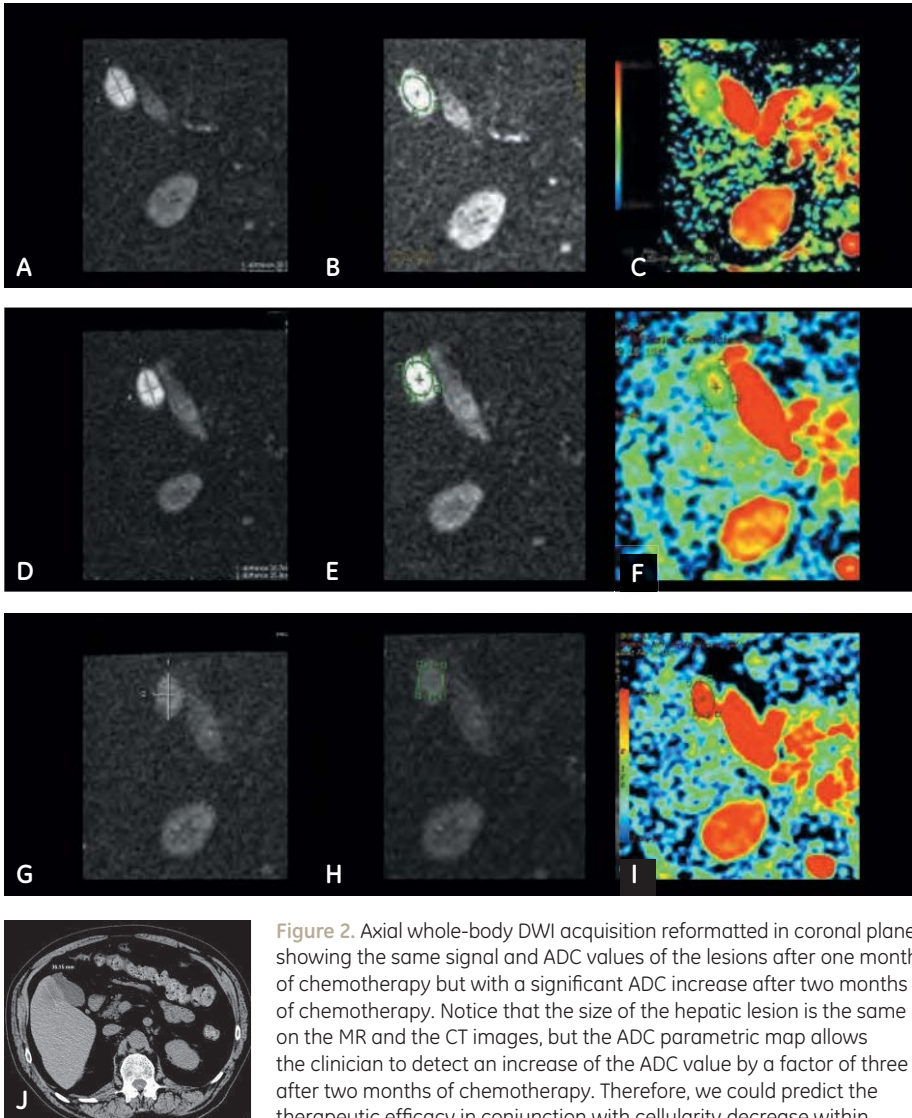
Axial whole-body DWI acquisition reformatted in coronal plane, showing the same signal and ADC values of the lesions after one month of chemotherapy but with a significant ADC increase after two months of chemotherapy. Notice that the size of the hepatic lesion is the same on the MR and the CT images, but the ADC parametric map allows the clinician to detect an increase of the ADC value by a factor of three after two months of chemotherapy. Therefore, we could predict the therapeutic efficacy in conjunction with cellularity decrease within the lesion.
